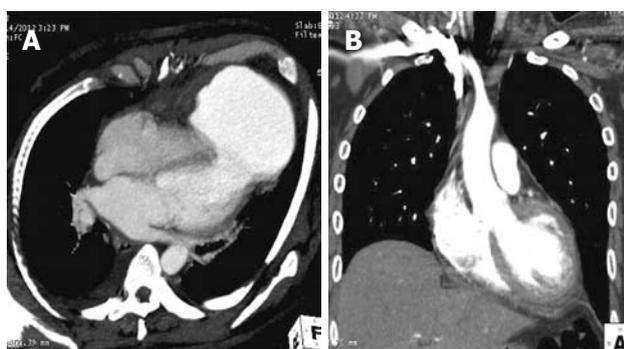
Computed tomography image of the heart. A: Computed tomography (CT) angiographic oblique axial image shows a rent of 28 mm at the left ventricle (LV) apex, communicating with a large 76 mm × 98 mm pseudoaneurysm; B: Post surgery, CT angiographic oblique coronal image in the plane of LV outflow tract shows well-delineated LV cavity without any pseudoaneurysm.
